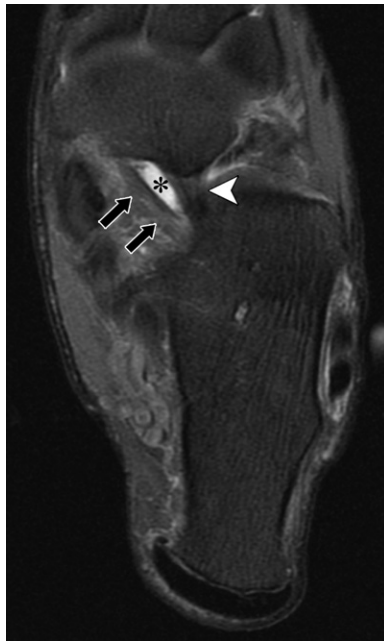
Normal spring ligament recess in an elderly man with symptoms of peroneal tenosynovitis. Axial fat-suppressed proton-density-weighted MR image of the foot shows a normal spring ligament recess (*) interposed between the medioplantar oblique (arrows) and inferoplantar longitudinal (arrowhead) bundles of the spring ligament. The normal recess is well defined, unilocular, and filled with homogeneous fluid. The principal differential diagnosis is a ganglion cyst, which tends to be larger, multilobulated, and septated. Tendinosis and/or the magic angle artifact is present and is causing graying of multiple tendons and the spring ligament. The magic angle artifact can be alleviated by performing MRI sequences with a long echo time at the expense of reduced signal-to-noise ratio.
